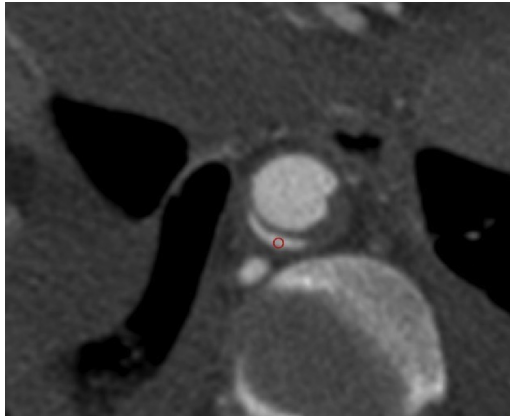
CTA and 3-D Reconstructed Image of the Aortic Dissection
